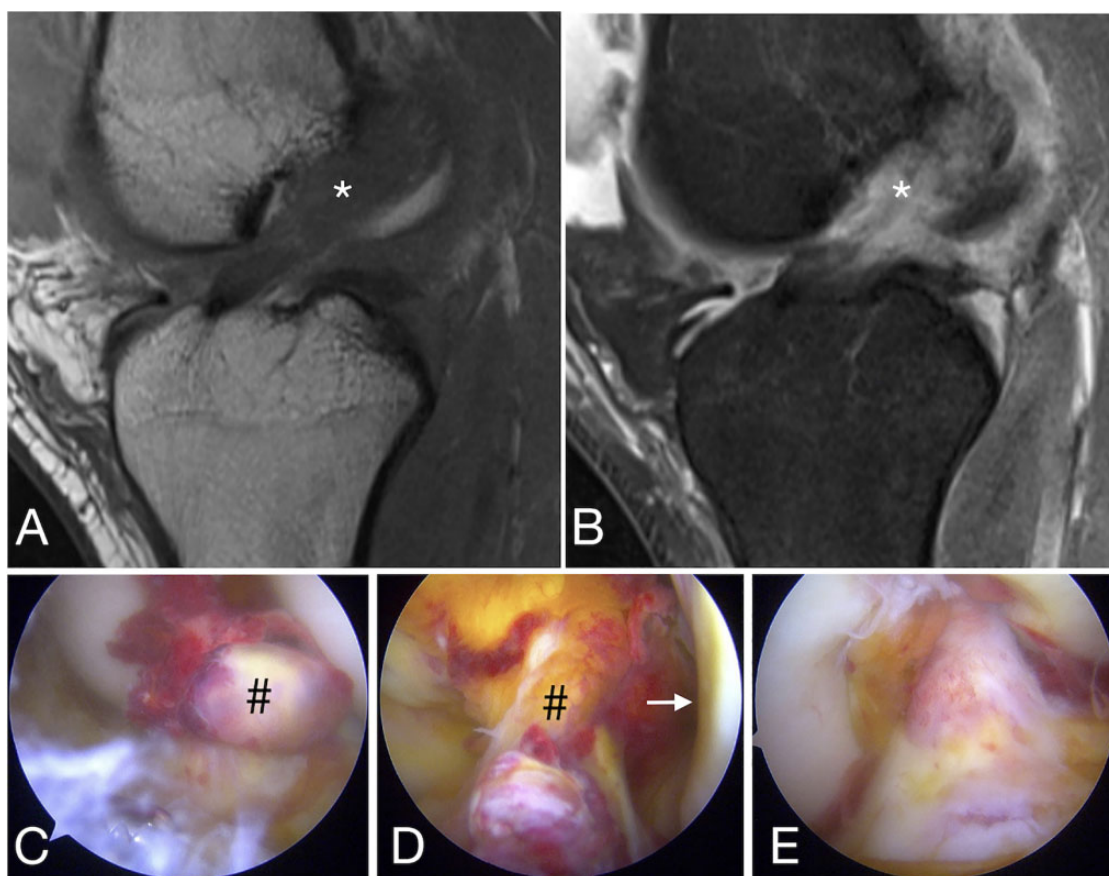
Preoperative magnetic resonance imaging scans and arthroscopic images at the time of surgery of the same knee. Sagittal (A) T1 and (B) T2 views of the knee show the region of the anterior cruciate ligament (ACL) rupture (*). Arthroscopic views of the same knee: (C) ACL rupture (#), (D) “empty wall sign” (arrow), and (E) after dynamic augmented ACL suture repair.
